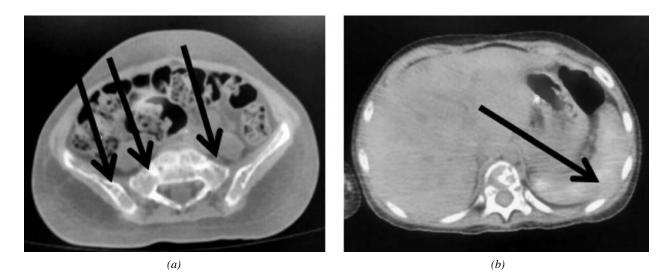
Fluorodeoxyglucose (FDG) PET scan showing extensive lytic changes in skeleton (a) with diffusely increased FDG uptake in spleen (b).
